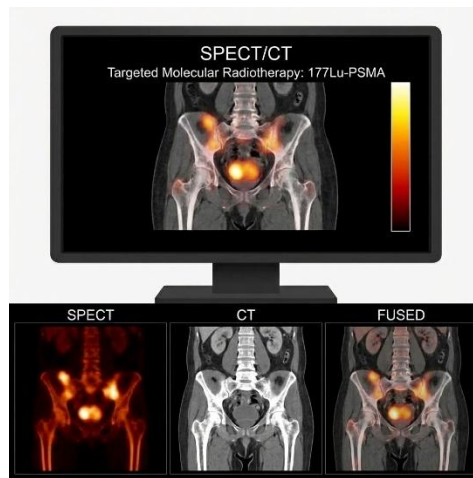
SPECT/CT imaging for targeted molecular radiotherapy in metastatic castration-resistant prostate cancer. (Image generated using artificial intelligence).
